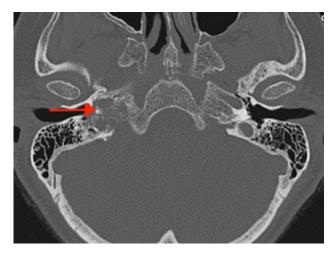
Axial CT temporal bone without contrast showing right glomus jugulare with classic irregular erosion and "moth eaten" appearance to temporal bone with extension to lower right CP angle and extending superolaterally towards hypotympanic region with erosive changes in the jugular bulb
